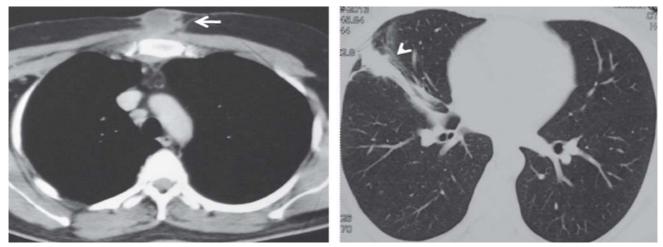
Contrast enhanced computed tomography of thorax done in 2013 demonstrating median cutaneous nodule (white arrow) and infiltrates, subsegmental collapse, fibrosis and traction bronchiectasis in the lateral segment of the right middle lobe and right pleural thickening (white arrowhead).
